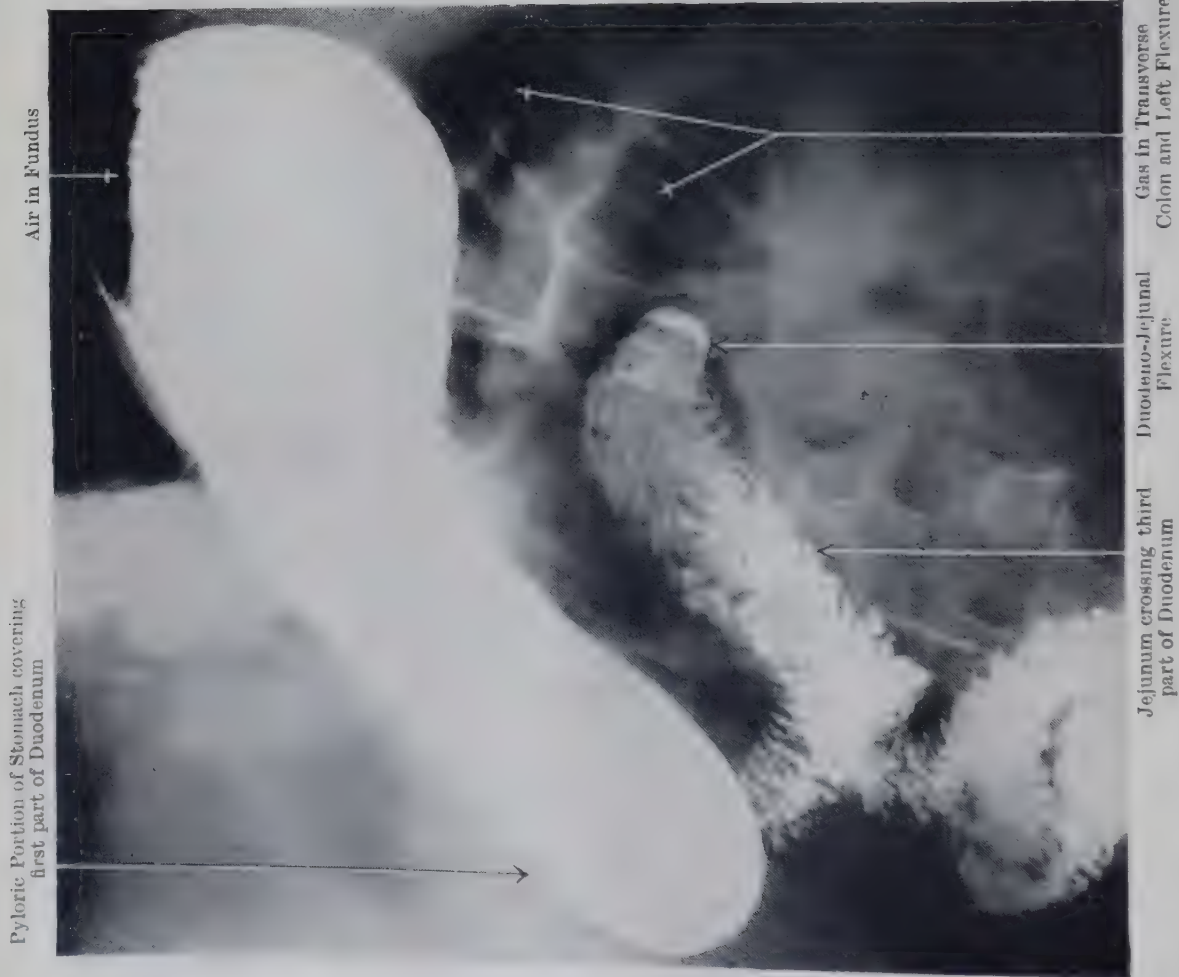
RADIOGRAPH OF "STEER-HORN" STOMACH OF MALE ADULT.
